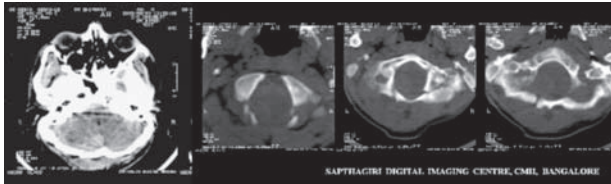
CT scan head 2 hours following trauma showing occipital fracture and thin posterior fossa hematoma.
